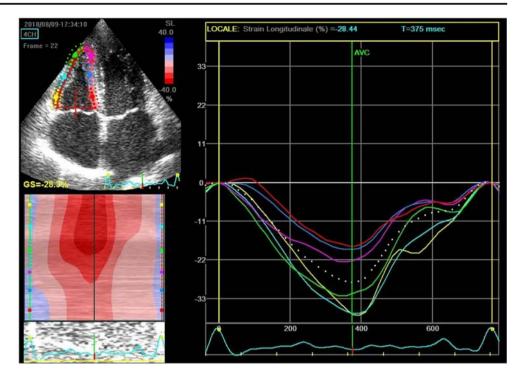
Global right ventricular longitudinal strain (RVLS). To perform the analysis, an apical four chambers with the complete inclusion of RV wall in the image must be acquired. The operator must accurately trace the endocardial border by a point-and-click approach, obtaining a region of interest composed of six segments (three at interventricular septum, three at free wall). The mean value of the longitudinal deformation of these six segments represents the global RVLS
